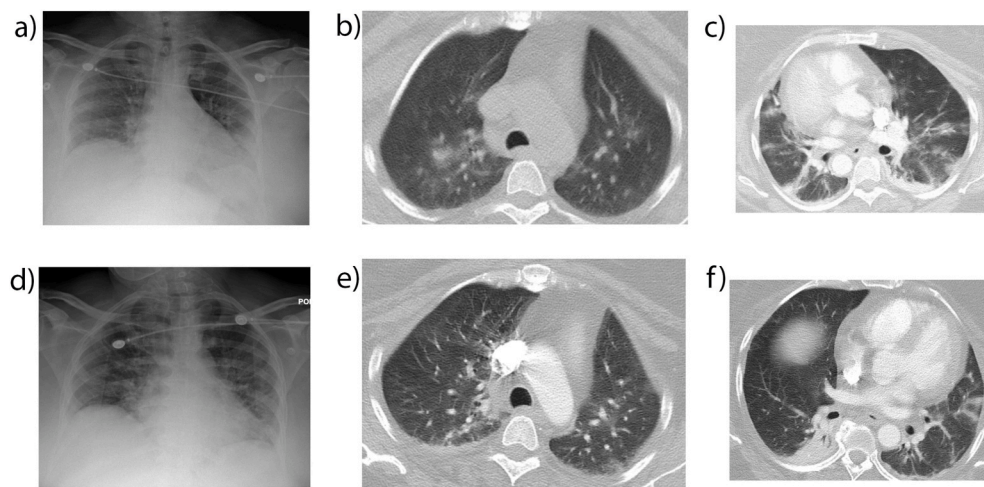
1A, 1B and 1C (From left to right clockwise): Admission CXR shows low lung volumes with left lower lobe peripheral parenchymal opacities. CT shows right upper lobe and bilateral lower lobe nodular areas of peribronchovascular and peripheral airspace opacification.
